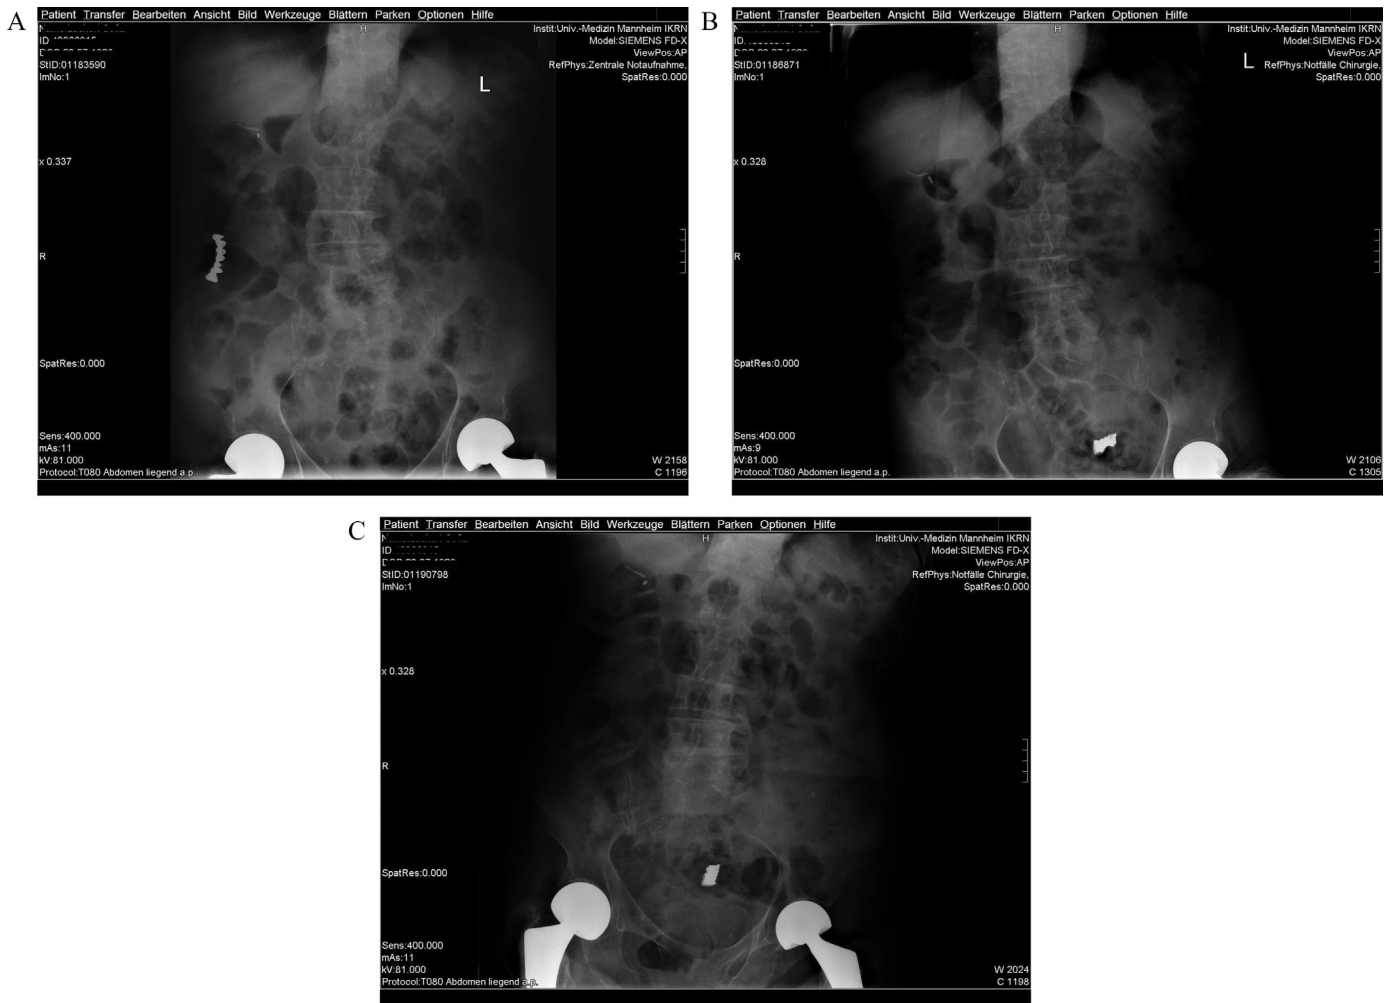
Conventional abdominal X-ray on initial presentation (A), after two days (B) and seven days (C).
